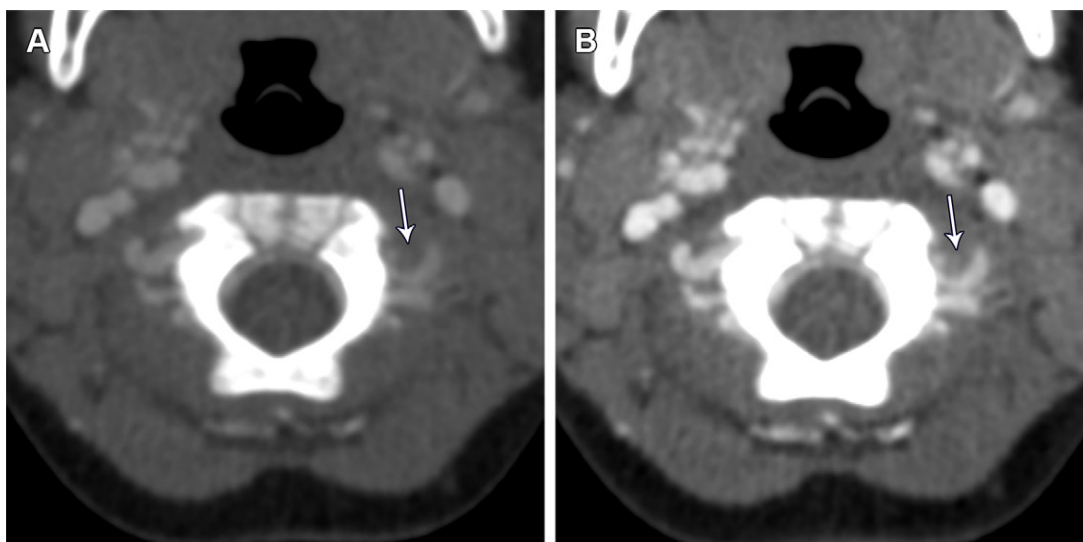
Left VAD in a 21-month-old girl. Low-kiloelectron-volt virtual monoenergetic reconstructions from dual-energy CT angiography may increase the conspicuity of VAD in cases of a poorly timed contrast agent bolus. (A) On the 70-keV virtual monoenergetic image, weak arterial enhancement and extensive venous contamination lead to poor visualization of the VAD (arrow). (B) On the 45-keV virtual monoenergetic reconstruction, the contrast-to-noise ratio is improved—due to an increased photoelectric effect just above the k-edge of iodine—and the conspicuity of the segmental stenosis and eccentric mural thickening of the left proximal V3 segment (arrow) is increased despite venous contamination.
